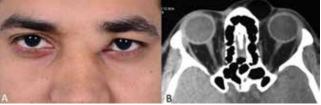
(*A*) Left internal angular orbital mass (*B*) Axial CT shows a cystic lesion in the left superomedial orbit, suggestive of dermoid.
